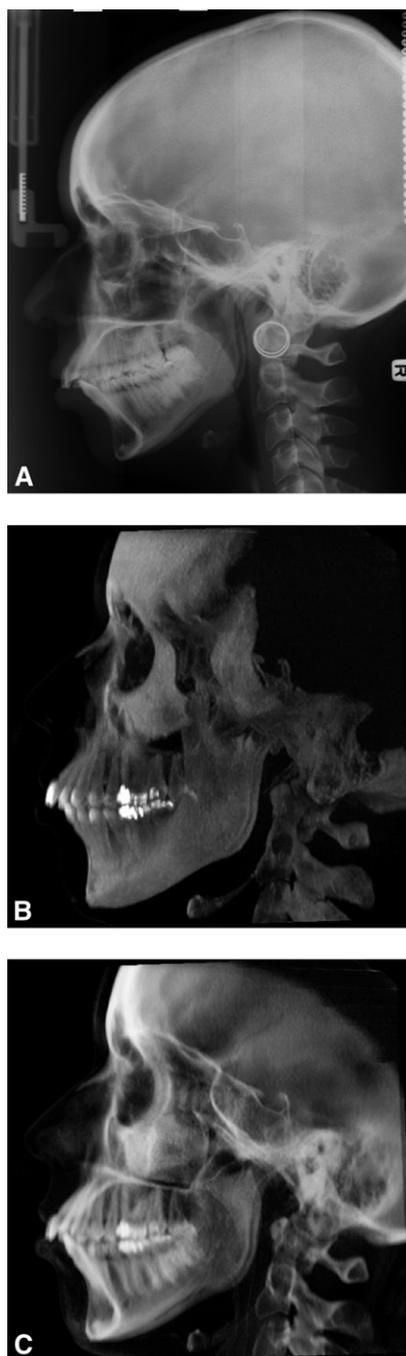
A, Conventional lateral cephalogram. B and C, CBCT-synthesized lateral cephalograms of the same patient: the MIP technique (B) and the RayCast technique (C).
